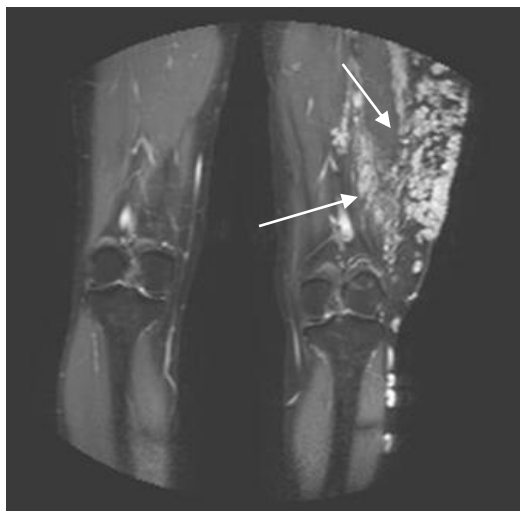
1. MRI scan of a left thigh LF AVM
